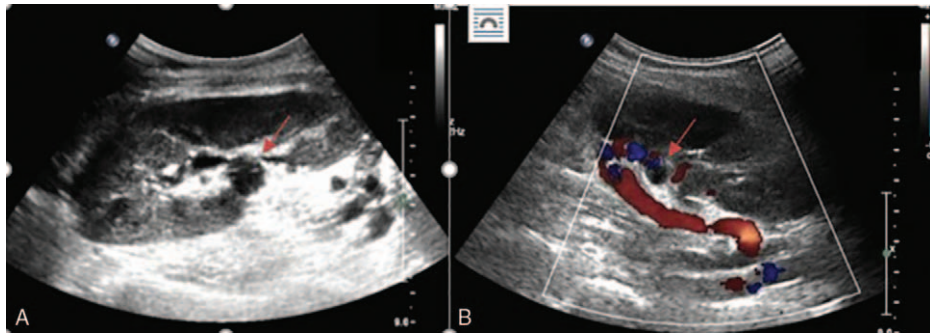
Ultrasonography (A) and color Doppler ultrasonography (B) images initially depicted 1 hypoechoic mass located in the hilum. CDUS=color Doppler ultrasonography, US=ultrasonography.
